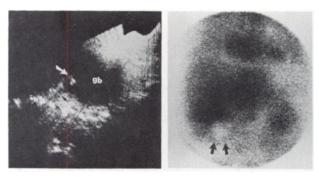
Case 4. Sonogram (left): gallbladder (gb) is enlarged with stones (white arrow) producing shadowing (black arrows). Tc-HIDA scintigram at 5 min (right): photon-deficient gallbladder fossa is seen (arrows); this persisted on views obtained to 24 hr.
